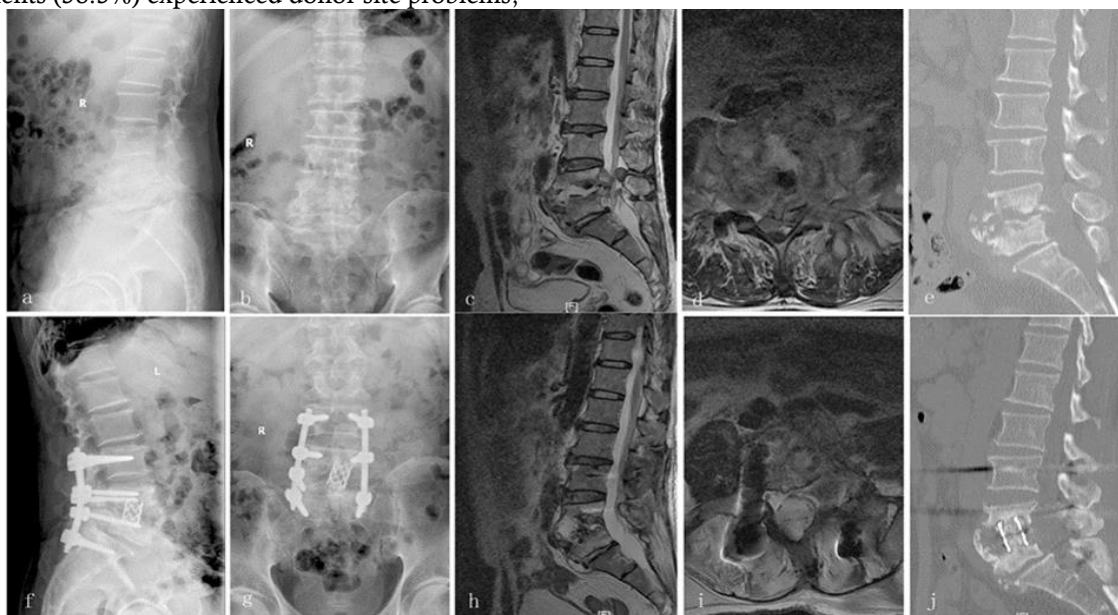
Using an internal fusion, titanium mesh cage, posterior-only debridement, and instrumentation, a 56-year-old male patient with lumbar TB (L4-5) was treated. L4-5 anterior and middle column damage with neurological impairment was seen on preoperative radiography (a and b), MRI (c and d), and CT (e). Bony fusion was achieved, as evidenced by radiography (f and g) obtained at the last follow-up. After surgery, the epidural abscess completely resolved, and the neural component decompressed, according to postoperative MRI (h and i) and CT (j).
